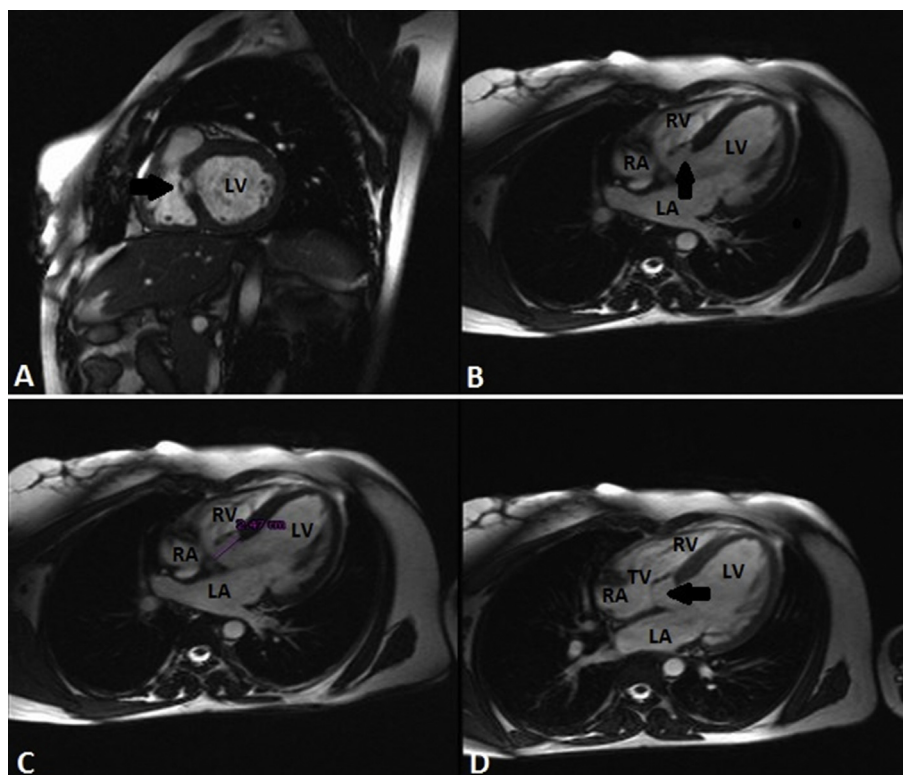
Cardiac magnetic resonance imaging shows ventricular septal defect and discrete subaortic membrane (arrows) (LA: left atrium, LV: left ventricle, RA: right atrium, RV: right ventricle, IVS: interventricular septum, TV: tricuspid valve).
